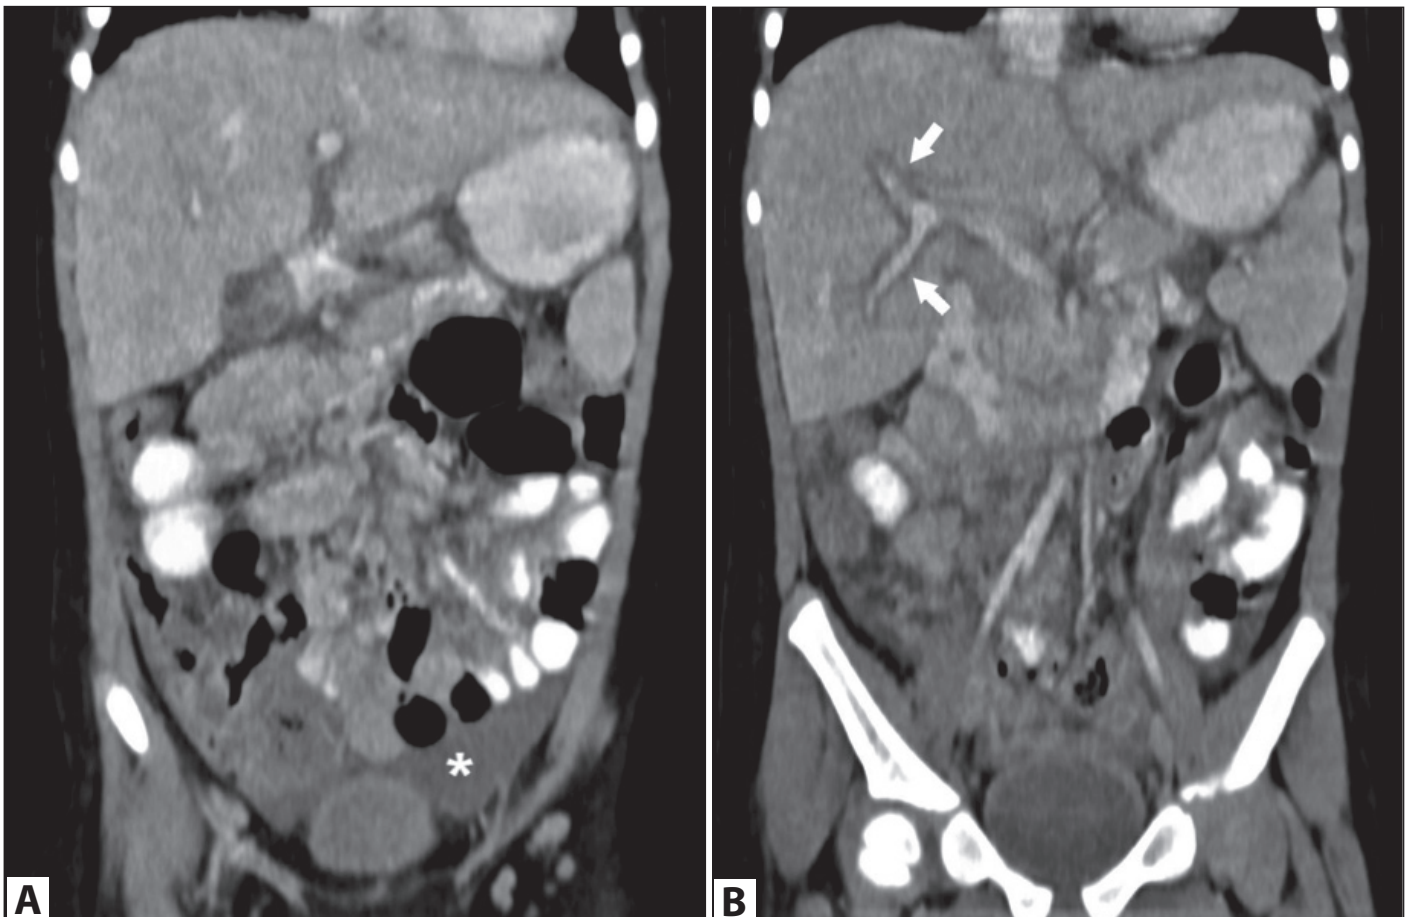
Coronal reformatted images of the contrast-enhanced abdominal CT slices.
